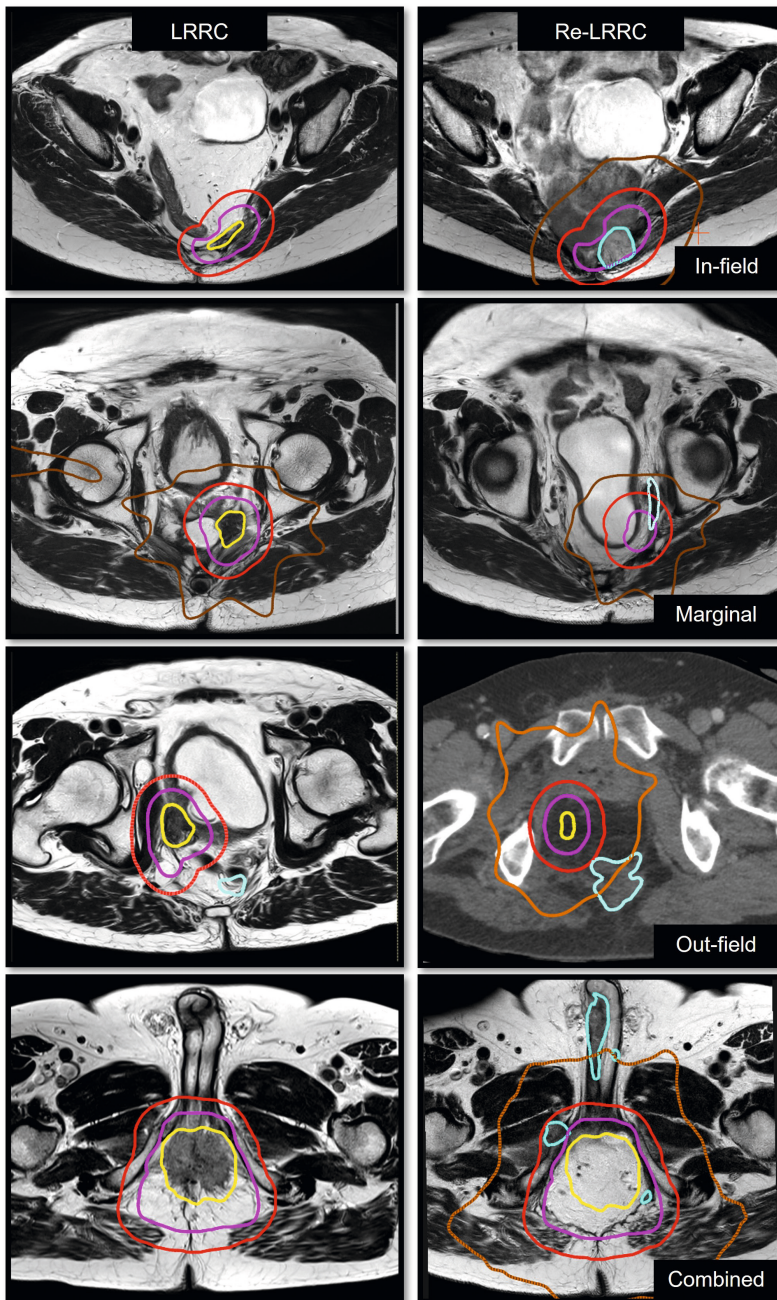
Examples of re-recurrences deemed in-field, marginal, out-field or combined compared to LRRRC target volume. MRI or CT of the LRRRC is shown on the left, and the re-LRRRC on the right. GTV (yellow), CTV (pink), and PTV (red), as well as the 50% isodose line (brown) is shown for the recurrence. The re-LRRRC is shown in blue. Target volumes may seem different from left to right as different slices were chosen for better visualisation.
